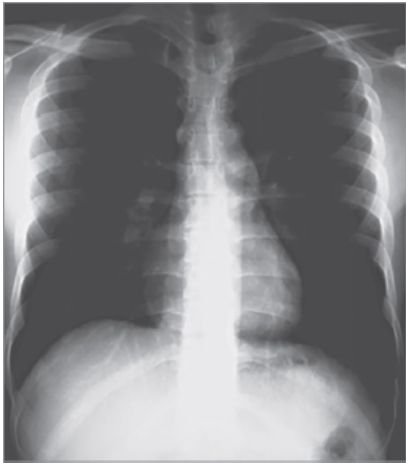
Black and white areas in X-ray.
